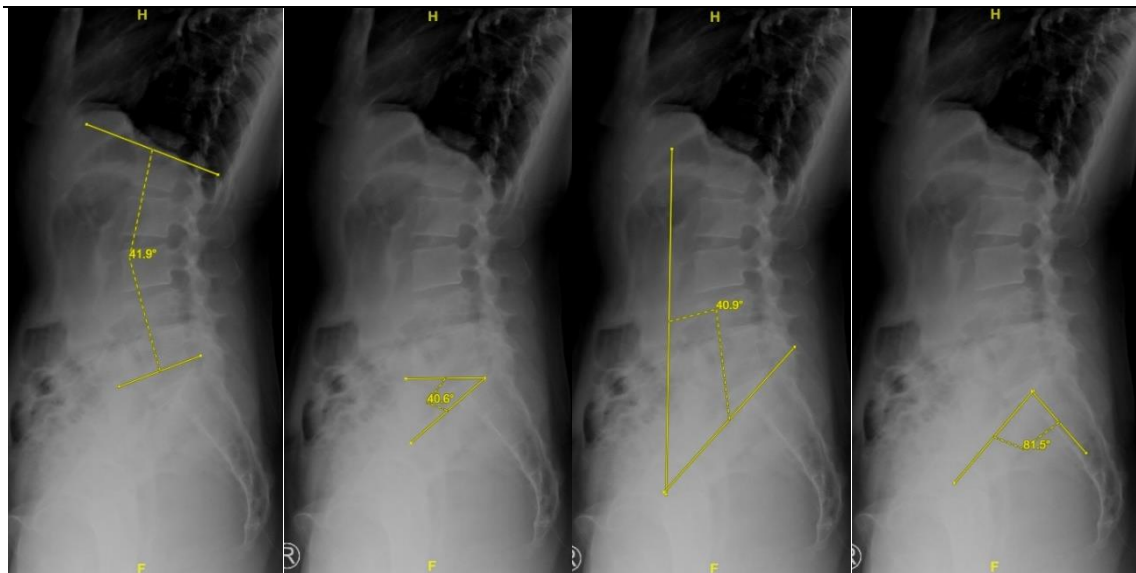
Thoracolumbar X-Ray at Hasan Sadikin Hospital, Bandung April 30th 2022
